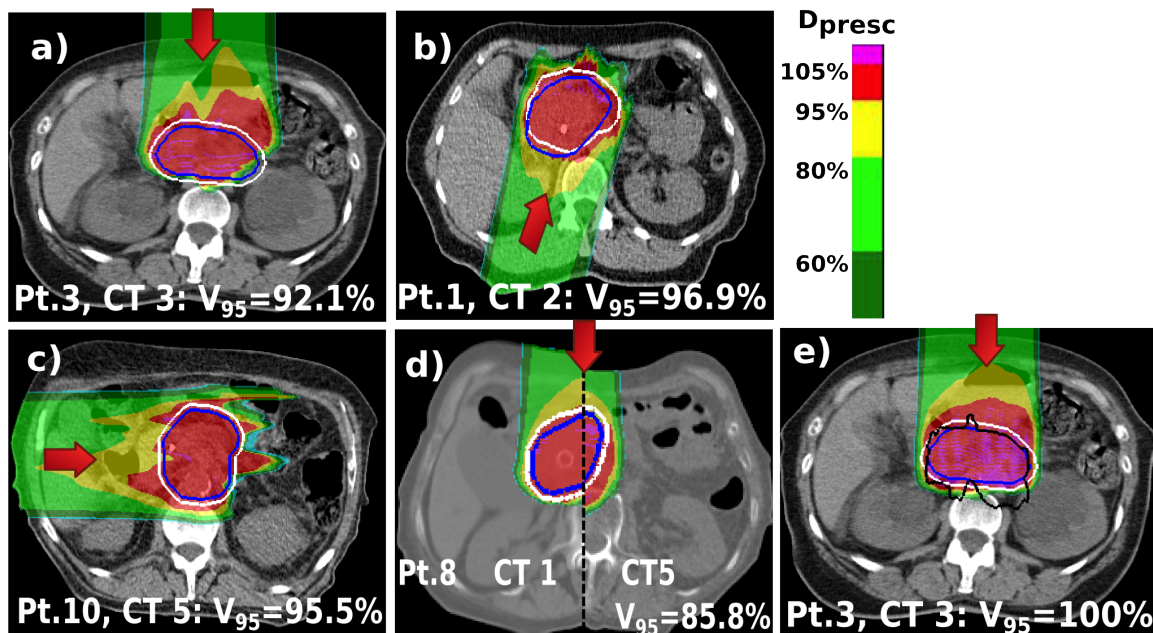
Forward dose distribution of the optimised plan for the ITVG5 (white contour) in one of the weekly CTs for four different patients exhibiting different inter-fractional changes. Depict is the value of the V_{95CTV} , in the respective CT, for the CTV (in blue). a) Patient A3 for an anterior beam as results of changes in the bowel/stomach. b) Patient A1 with an oblique posterior beam showing tumour deformation. c) Patient A10 planned with a lateral right beam with bowel and liver position alterations. d) Patient A8 for an anterior beam exhibiting an accentuated weight loss between the CT₁ and CT₅. e) Dose distribution for the same CT and patient as in the figure a) but showing the retrospectively determined ITV_{WEPL} (black contour) in comparison to the ITV_{G5} and the dose distribution for the new optimisation.
